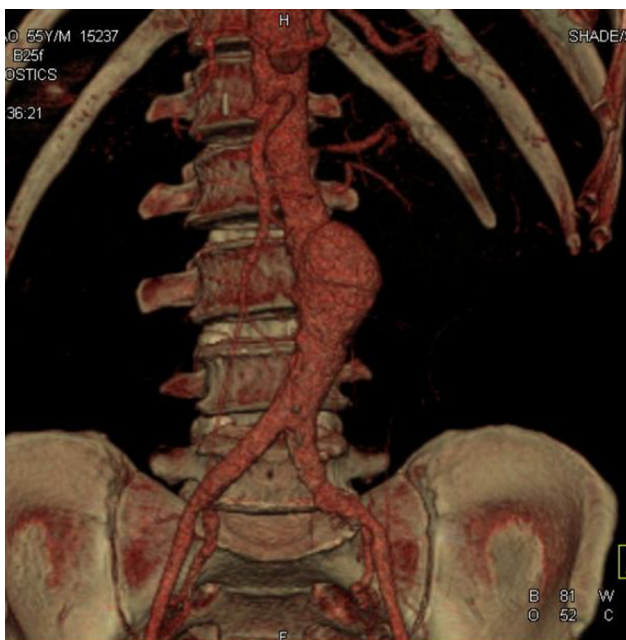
CT angiogram showing abdominal aortic aneurysm and renal artery stenosis.
